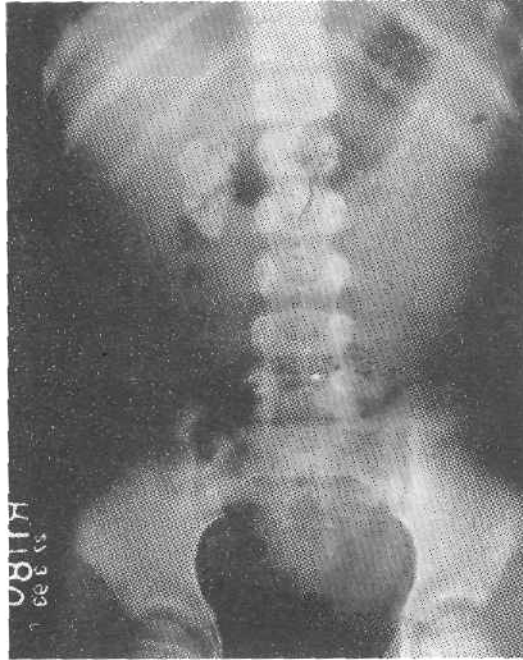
Plain X-ray abdomen showing calcification in right kidney.
